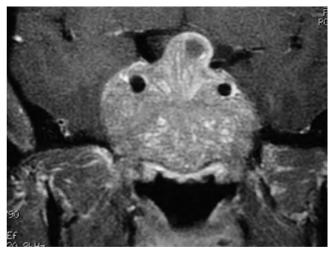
Coronal magnetic resonance image showing a large pituitary adenoma with disruption of the sellar diaphragm, predisposing to an intraoperative CSF leak.
